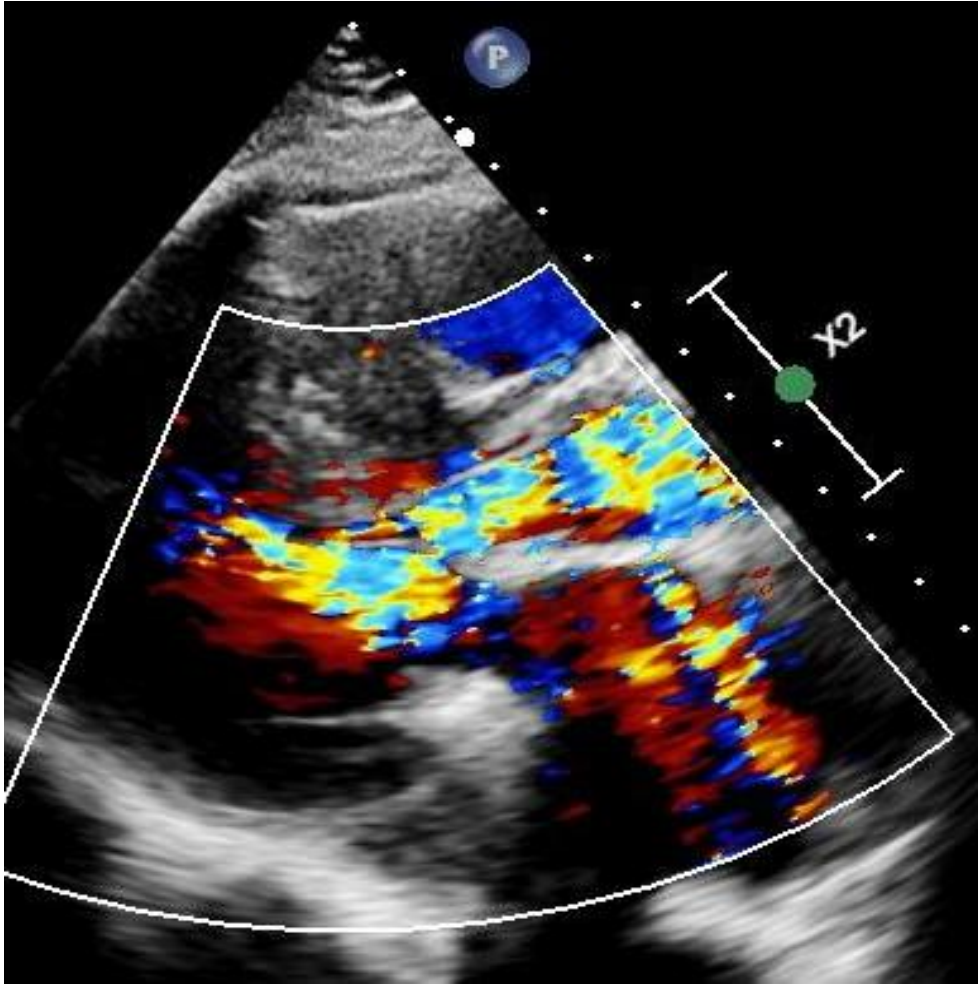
Color Flow Doppler shows LVOT flow turbulence due to LVOT obstruction
